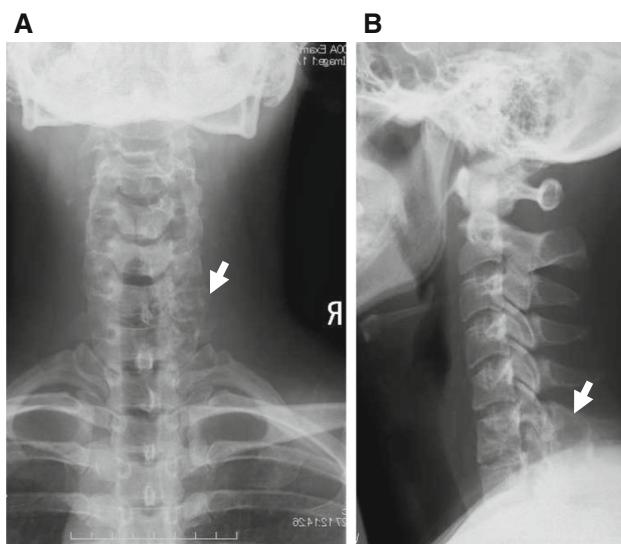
a, b Plain cervical X-rays revealed a radiolucent lesion located in the pedicle and facet on the right side that was visible in the anteroposterior view of C6–C7 (arrow)
